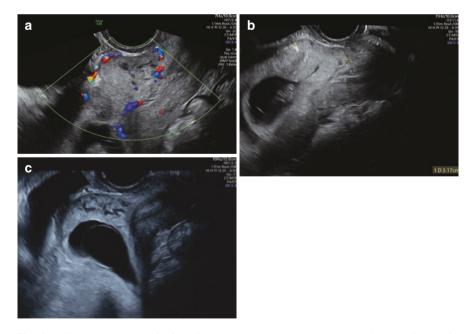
Ultrasound images of a first trimester pregnancy with cesarean scar implantation; (a, b) sagittal image of the lower uterine segment with extension of the decidua into the myometrium at 8 weeks; (c) sagittal image of the same pregnancy at 9 weeks with formation of lacunae
